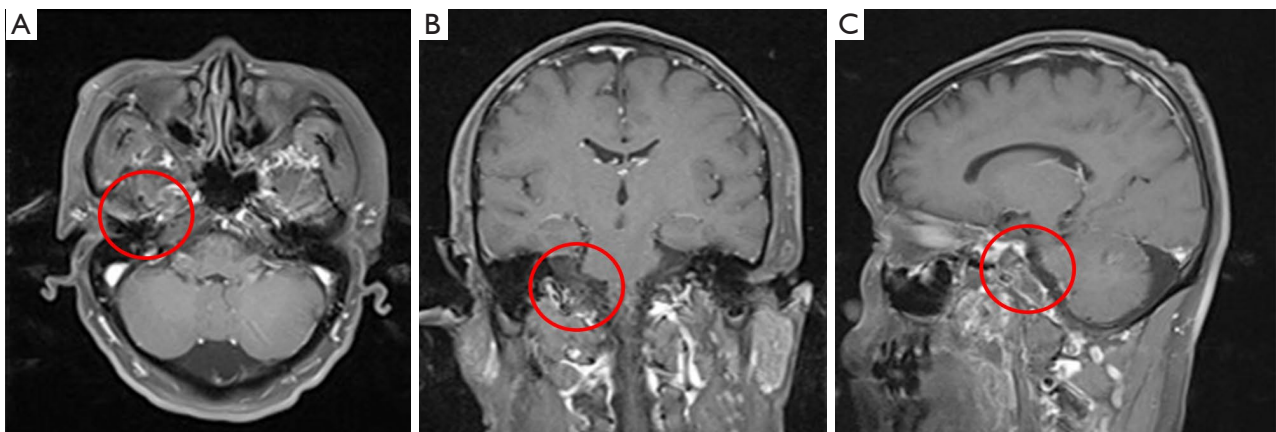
The postoperative 10-month follow-up enhanced cranial MRI (October 1, 2023). (A) Axial, (B) coronal, and (C) sagittal views of show no obvious enhancement or proliferative tissue in the surgical area. The location of the tumor operative zone is circled in red in the figure. MRI, magnetic resonance image.
